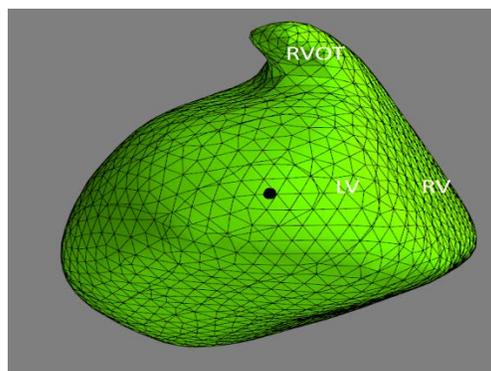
Epicardial polygonal MRI model imported into custom written software with Python. Black dot – central marker of late activation zone.
